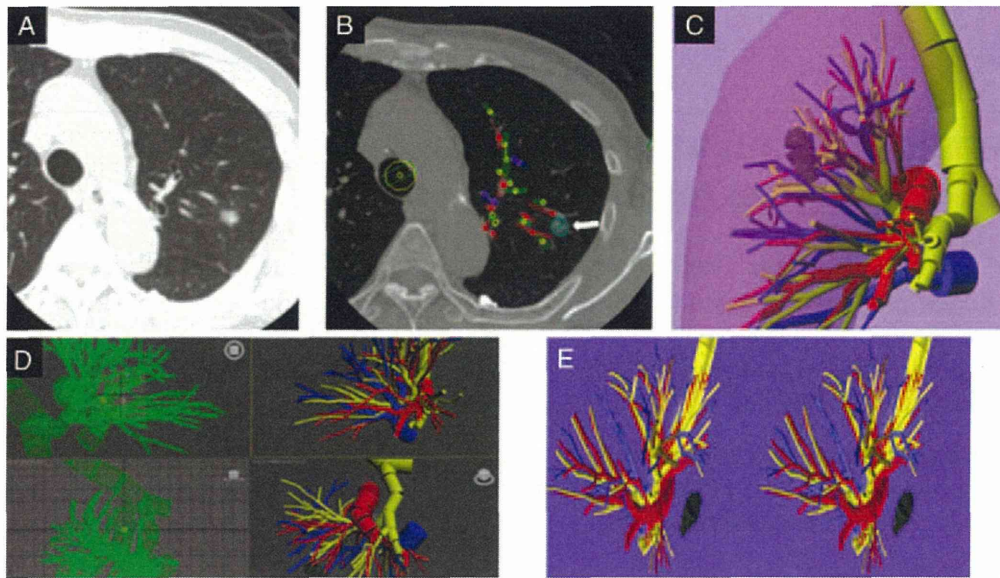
(A) Chest CT image shows a primary lesion as ground glass opacity in 2 segments (S1 + 2 and S3) of the left upper division. (B) Locations and thicknesses of tumor. Yellow dots indicate the bronchi; red dots, the pulmonary arteries; blue dots, the pulmonary veins; white, tumor, which were rendered as different-sized cylinders by the home-made software program (CTTRY). The striped rectangles of each color were a trace of the dots of each color. (C) Virtual 3-D image was reconstructed using shareware (Metasequoia). Yellow indicates the trachea and bronchi; red, pulmonary arteries; blue, pulmonary veins; the veiled area, the lung. (D) Data of the reconstructed 3-D images were converted with Autodesk® 3ds Max® 2012. (E) REMO Exporter®, which reproduces Autodesk 3ds Max data with real-time CG, can indicate with a stereoscopic vision display by 3-DCG data. On a PC, reconstructed 3-D pulmonary images were provided side-by-side and were output to a monitor. Dark yellow indicates the stapled bronchi; dark blue, resected pulmonary veins.
